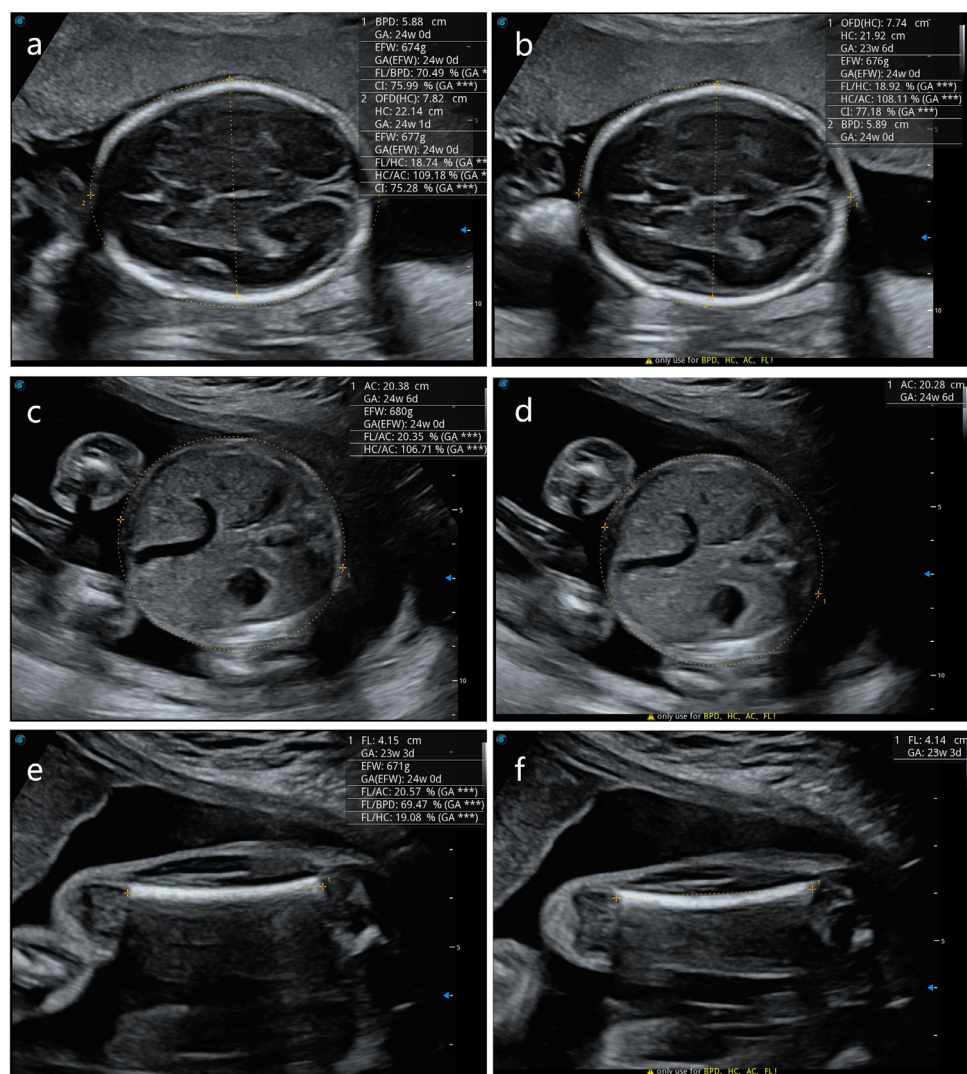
Sections acquired and parameters measured with the traditional ultrasound technique (TUT) and Smart Fetus acquisition (SFA). (a) Acquisition of a transverse section of the thalamus and measurement of biparietal diameter (BPD) and head circumference (HC) with TUT. (b) Acquisition of a transverse section of the thalamus and measurement of BPD and HC with SFA. (c) Acquisition of a transverse section of the abdomen and measurement of abdominal circumference (AC) with TUT. (d) Acquisition of a transverse section of the abdomen and measurement of AC with SFA. (e) Acquisition of a longitudinal section of the femur and measurement of femur length (FL) with TUT. (f) Acquisition of a longitudinal section of the femur and measurement of FL with SFA.
